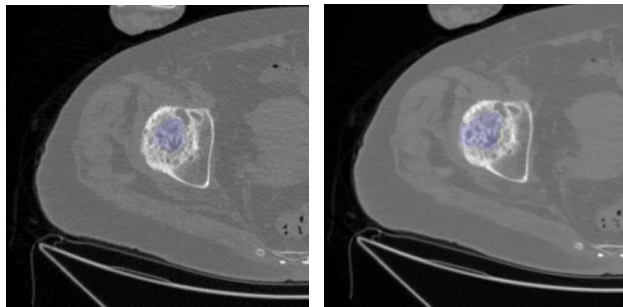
The first slice detecting the start of the femoral head for patient 2 Left) 1mm Right) 3mm. The purple region denotes the area that *Simini* automatically selected as femoral bone. Both instances fail to properly extract femoral bone due to the many tumors. A slightly larger region is extracted in the 3mm ST CT scan compared to the 1mm.
